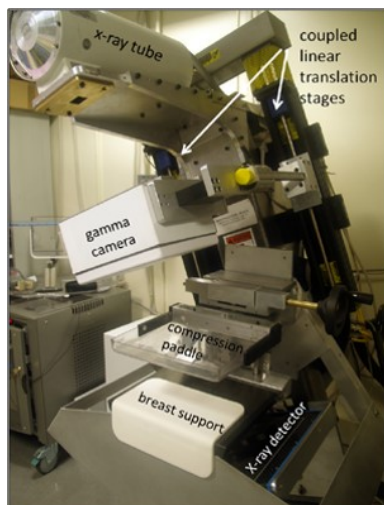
A photograph of the Dual Modality Tomosynthesis system. The imager is capable of acquiring x-ray transmission data for tomosynthesis and functional data from the gamma camera with the breast under mild compression. Photography reproduced from the University of Virginia (<http://faculty.virginia.edu/mbwlabwebsite/DualModalityTomosynthesis.html>).
